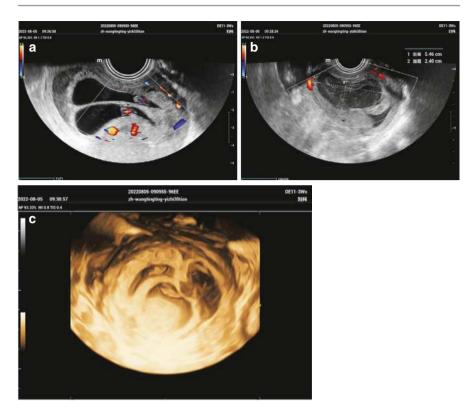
(a) DCDA twin pregnancy with intrauterine hemorrhage, 35 days post transplantation: two gestational sacs are visible in the uterine cavity, each containing an embryonic structure. Fetal heartbeats are detected on CDFI. (b) Intrauterine fluid is observed within the uterine cavity, with punctate and flocculent echoes. No blood flow signals are detected on CDFI. (c) 3D ultrasound showing two gestational sacs and fluid in the uterine cavity
